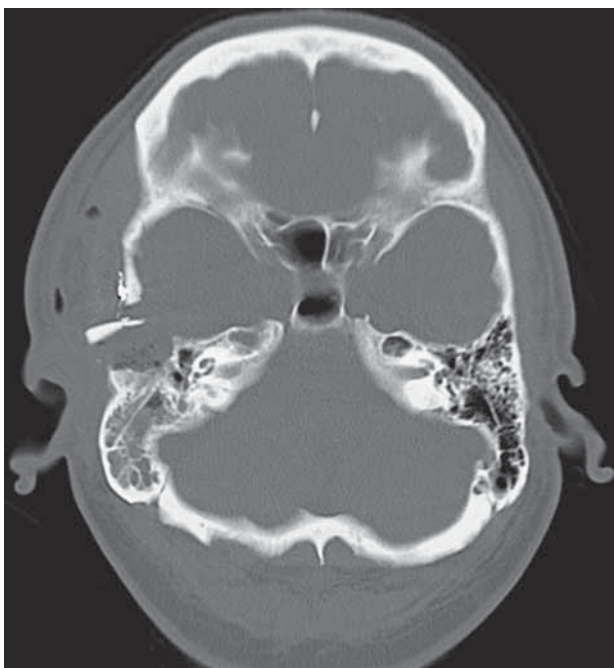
Immediate postoperative axial CT scan in bone algorithm reveals a surgical bed with smooth bony margins.
